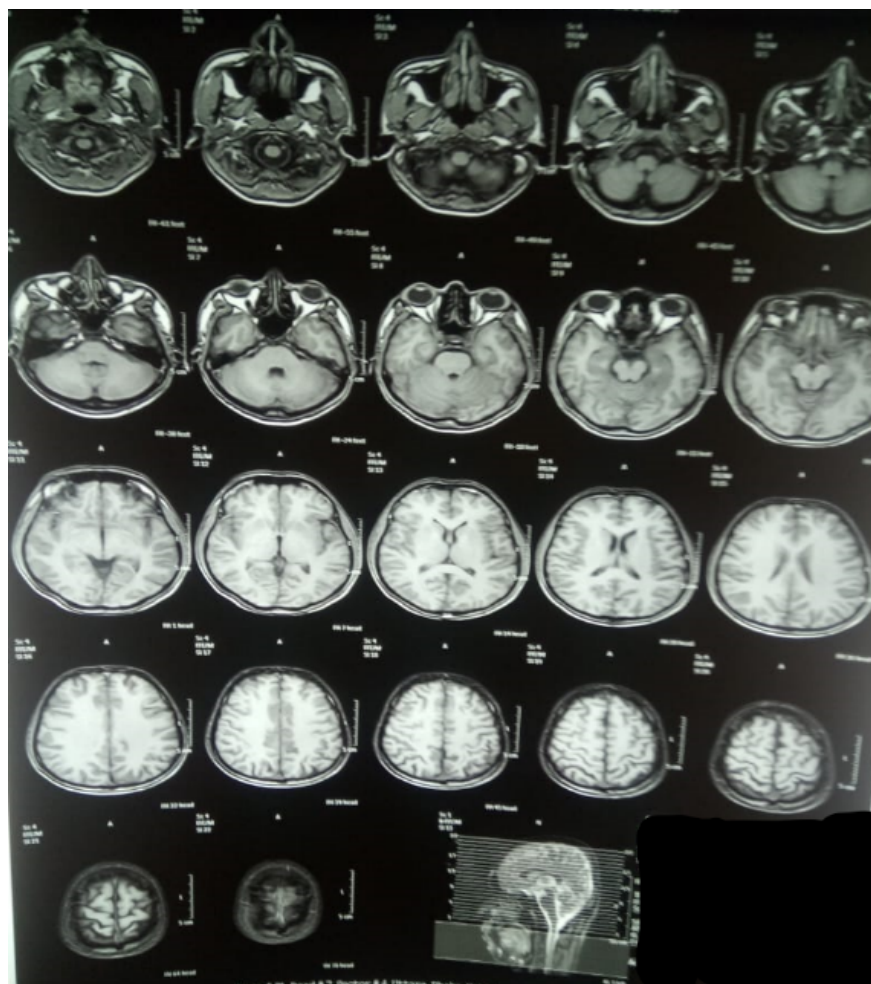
Computed Tomography (CT) scans of the case: CT demonstrated absence of Left IJV.
